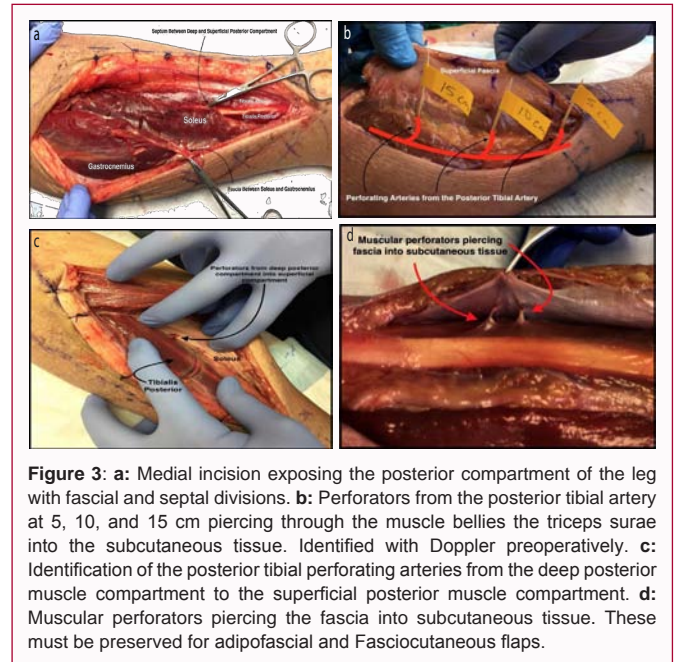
a: Medial incision exposing the posterior compartment of the leg with fascial and septal divisions. b: Perforators from the posterior tibial artery at 5, 10, and 15 cm piercing through the muscle bellies the triceps surae into the subcutaneous tissue. Identified with Doppler preoperatively. c: Identification of the posterior tibial perforating arteries from the deep posterior muscle compartment to the superficial posterior muscle compartment. d: Muscular perforators piercing the fascia into subcutaneous tissue. These must be preserved for adipofascial and Fasciocutaneous flaps.
